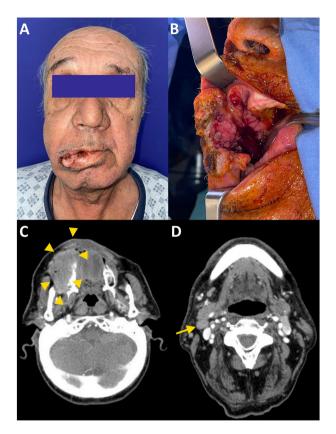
Preoperative (A and B) clinical and (C and D) computed tomography imaging features. Large infiltrative and ulcerating mass (C, arrowheads) associating with an upper jugular anterior tumoral lymph node (D, arrow).
